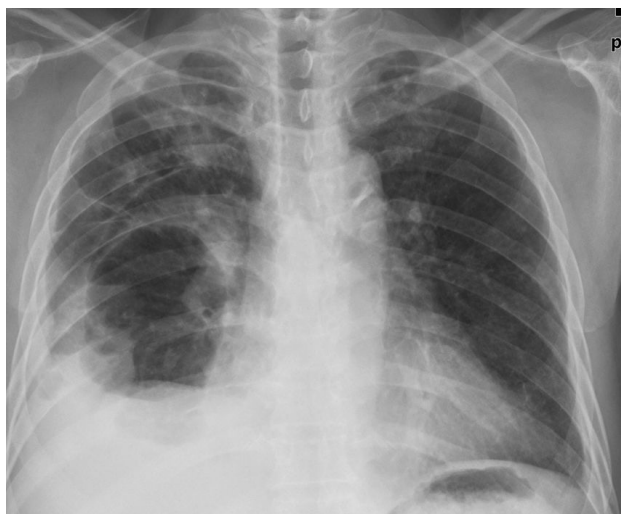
On the fifth day of hospitalization, chest radiography showed a newly developed air-cyst and air fluid level in the right lower lung.
